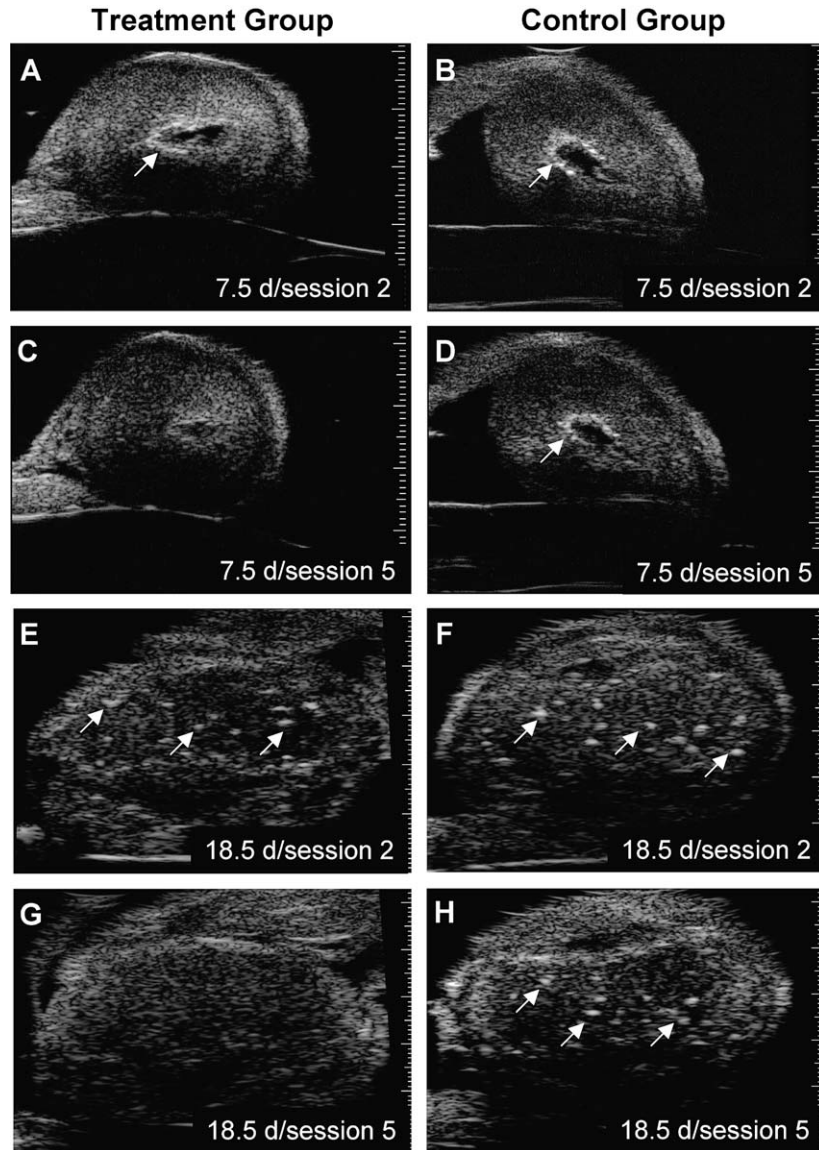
Ultrasound images from the implantation region of uteri at day 7.5 of gestation (A–D) or at day 18.5 (E–H) following fixation *in vitro* in 70% ethanol (A, B and E, F; session 2 of decalcification study). Arrows point to echogenic foci. Echogenic foci remained prominent in uterine segments from the control group (D, H) whereas treatment with a decalcification solution for 3 days resulted in a marked reduction in echogenicity in this region by session 5 of the study (C, G).
